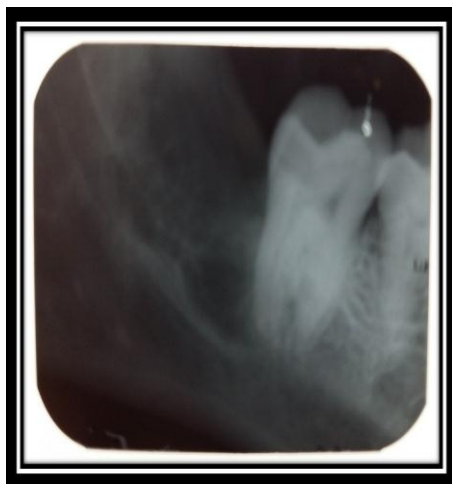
1 month post-operative Intra-Oral Periapical Radiograph.
